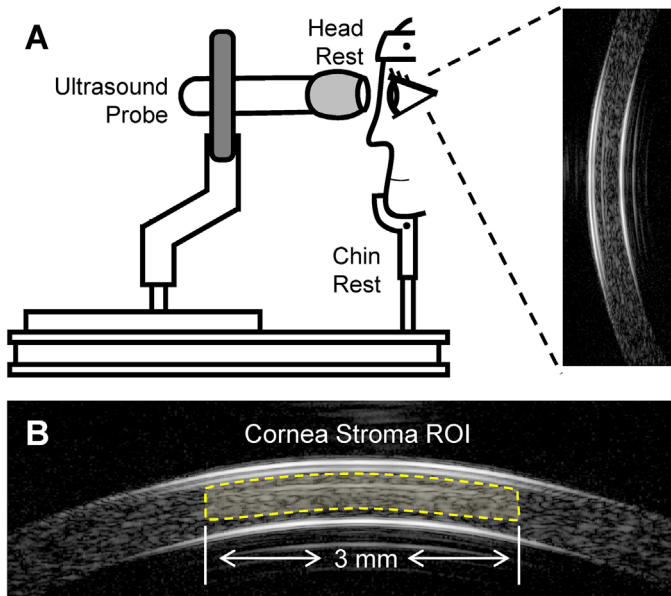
(A) The subject is stabilized for the OPE measurement with the head secured to a chin-and-head rest mounted on an anti-vibration table. One thousand frames of ultrasound B-mode images and RF data of the cornea centered at the apex are collected over a period of 8 seconds. (B) The central 3-mm corneal stroma is automatically segmented out as the region of interest (ROI) for OPE analysis.
